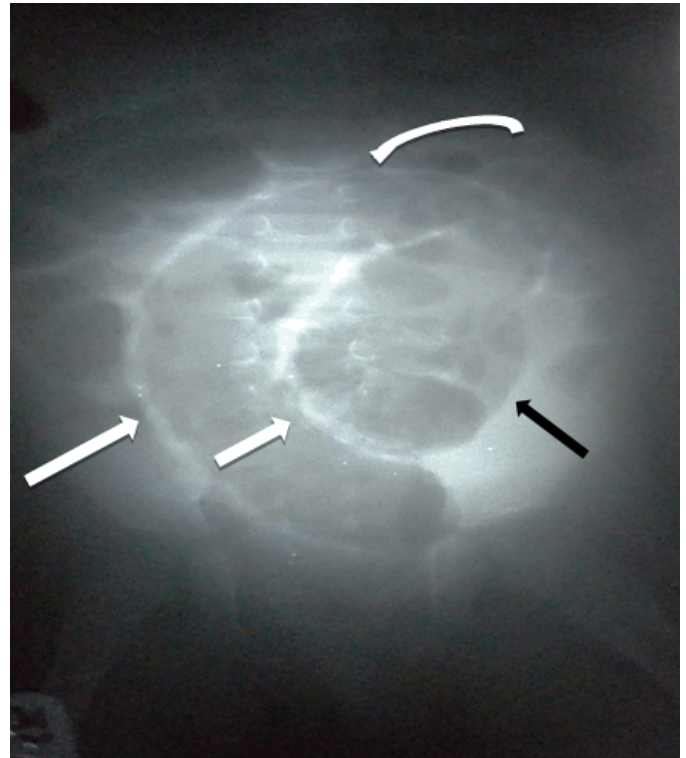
Plain abdominal radiograph (supine view) showing an inverted U-shaped dilated large loop of bowel arising from the pelvis and extending into the central abdomen to the level of the 12th thoracic vertebra. The loop exhibits three opaque stripes (long straight white arrow on the right, short straight white arrow centrally and black arrow on the left). The apex of the loop is on the left side of the midline (curved white arrow). This gives the classical “coffee bean” sign.
